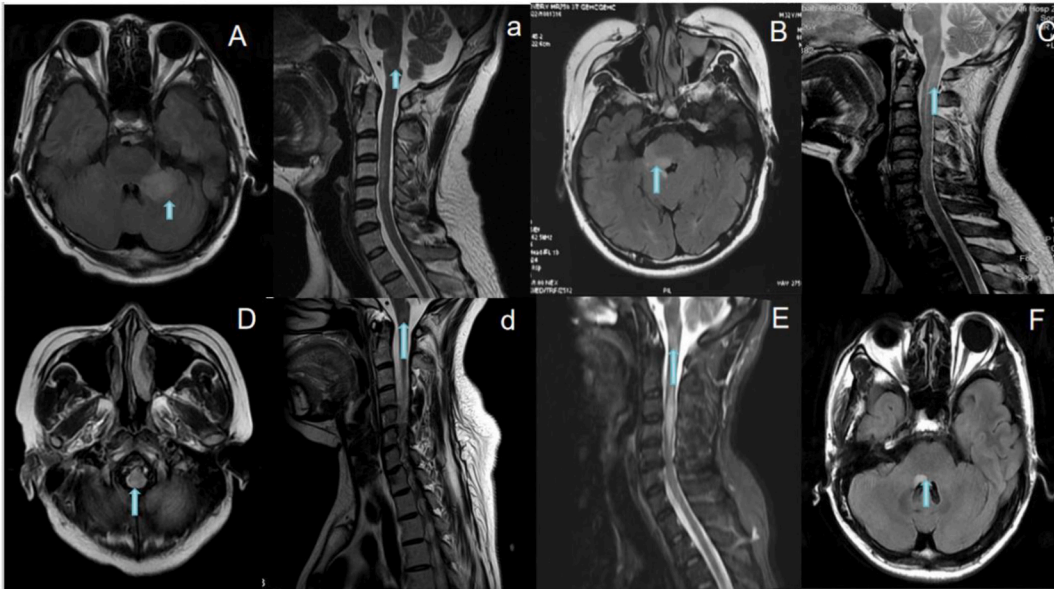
T2-weighted fluid-attenuated inversion recovery and Sagittal T2-weighted scan show lesions in the area postrema (AP) and multifocal lesions in the medulla and cervical spinal cord.
